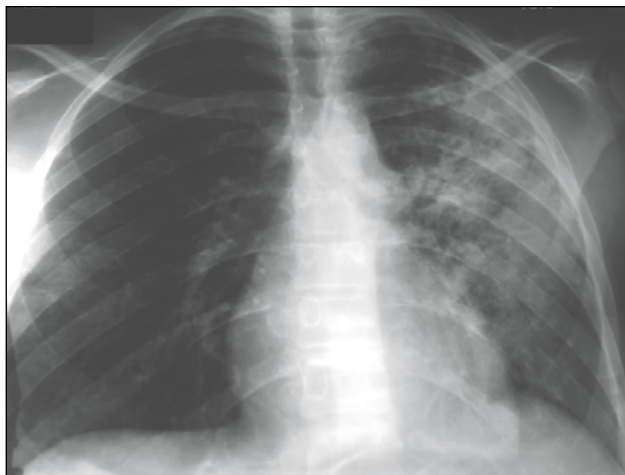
Radiograph showing predominant left-sided consolidation with cavitation and air-bronchograms.
